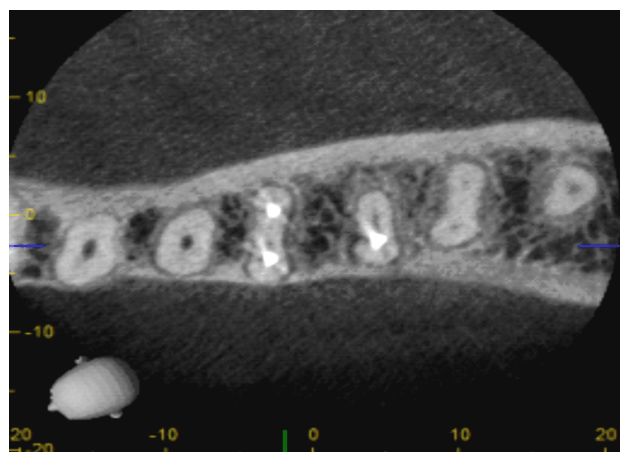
Preoperative transverse CBCT image showing three mesial root canals in tooth 36. The mesiobuccal and mesiolingual canals were previously instrumented and obturated. The middle mesial root canal is still untreated. A second untreated distal canal is also displayed. CBCT: Cone-beam computed tomography.
